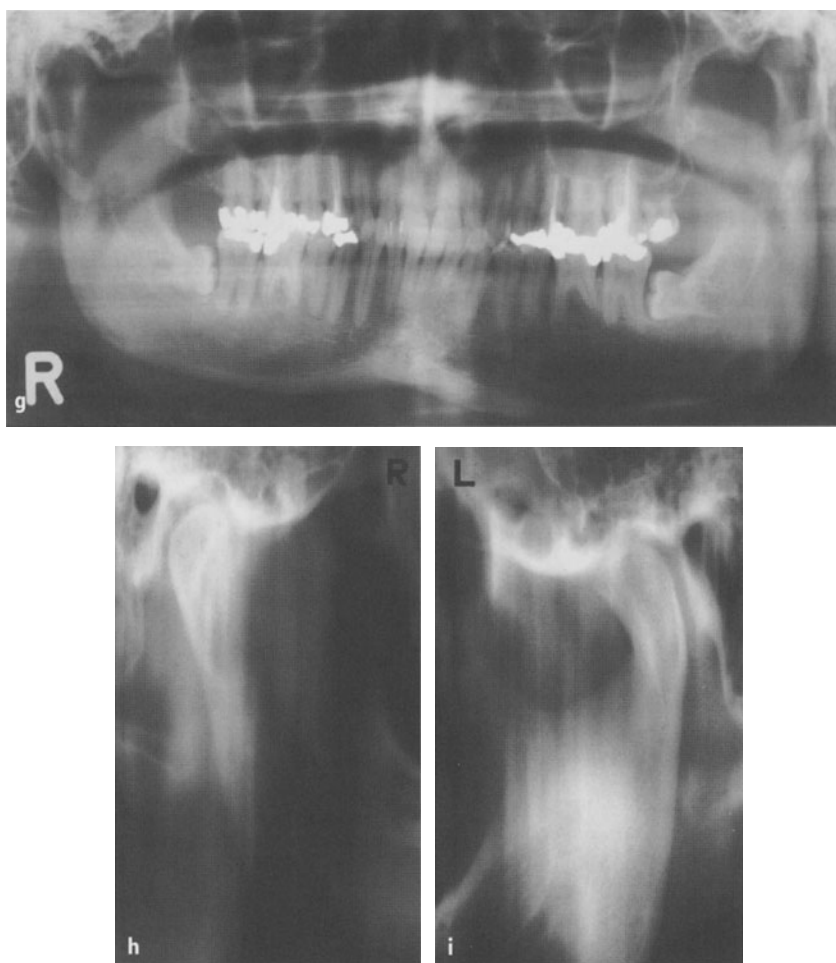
Questionable bilateral H.H. g The panoramic radiograph shows on the right side of the mandible all the characteristic signs of a H.H. and even more so on the left. There is a rounded translucency at the left angle, typical of a so-called pseudo-cyst caused by the impression of an enlarged lobe of the submandibular gland. h, i The tomograms of the mandible in the p.a. projection in the open mouth position show, on the right side, a very large condyle of probably normal shape and on the left the characteristic enlargement and deformity of a H.H.
